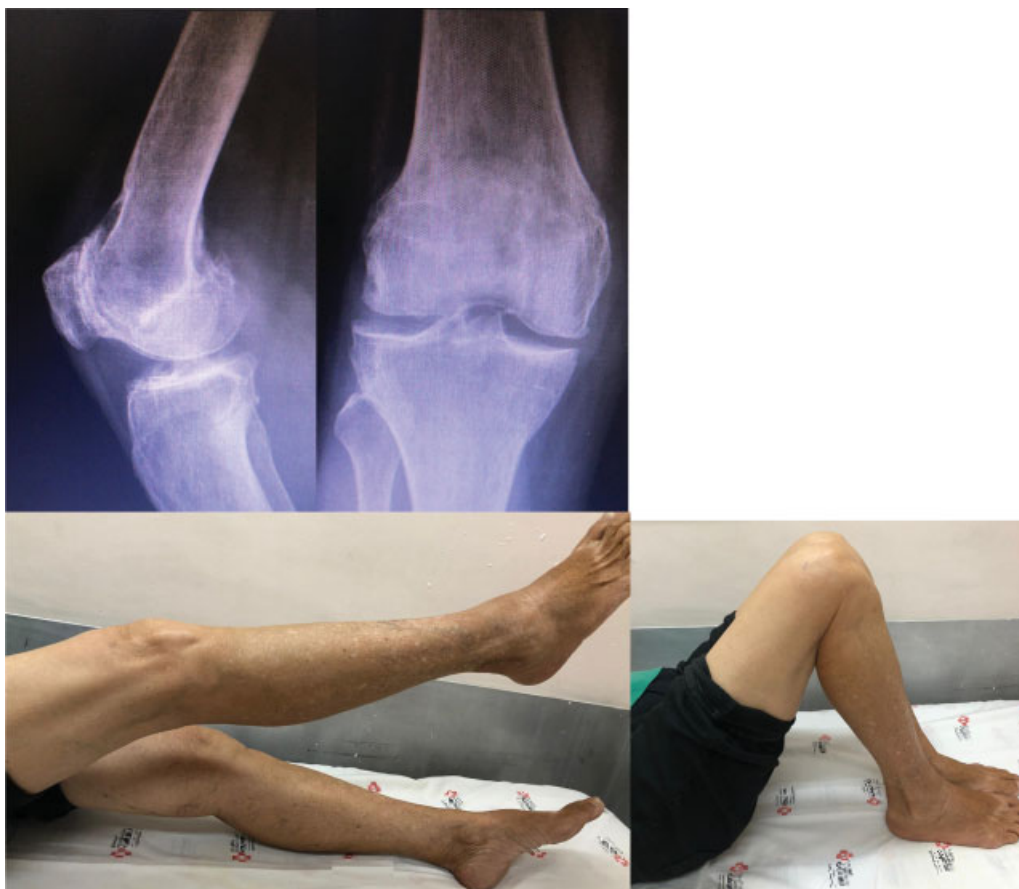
Control radiographs and range of motion after 2 years of evolution.
